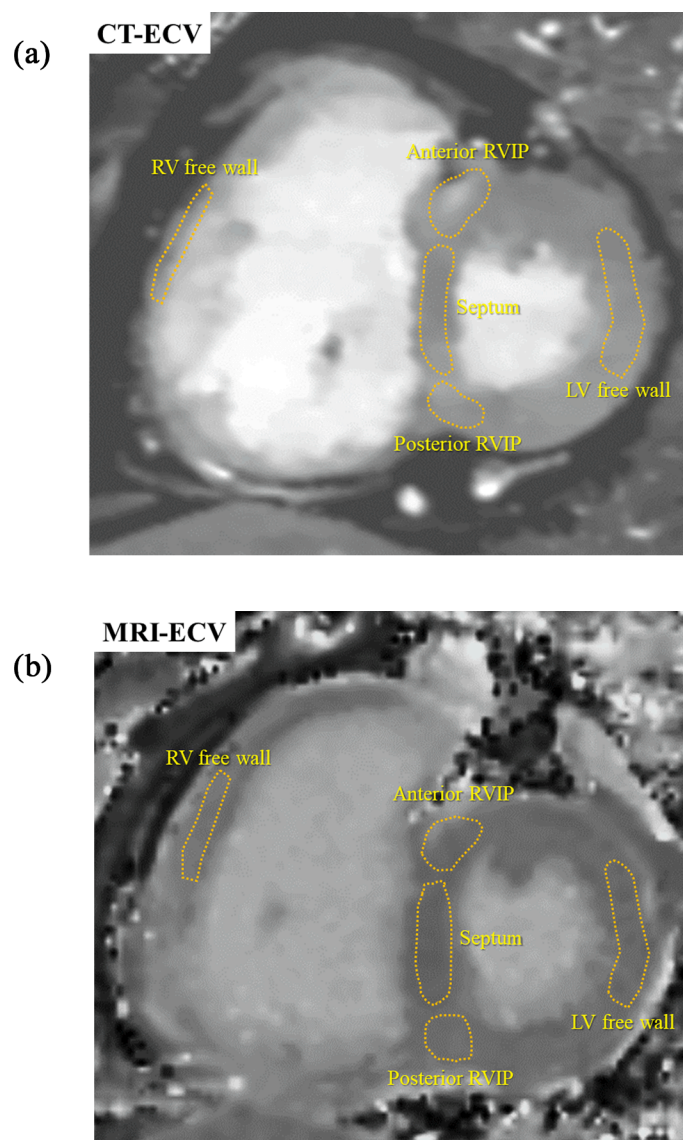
Quantitative extracellular volume fraction (ECV) measurements. Quantitative ECV measurements were performed using (A) a computed tomography (CT) ECV map and (B) a magnetic resonance imaging (MRI) ECV map. The ECVs were measured at the anterior right ventricular insertion point (RVIP), septum, LV posterior RVIP, left ventricular (LV) free wall, and right ventricle (RV) free wall in the LV short-axis view of the mid-ventricular level.
